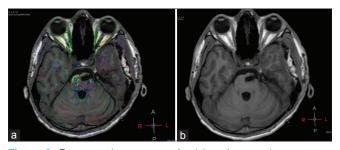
Postoperative tractography (a) and magnetic resonance imaging T1-weighted images (b) Complete excision of cavernoma and preservation of corticospinal tracts
